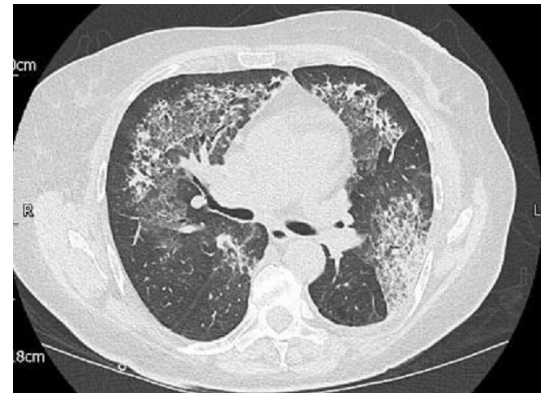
High-resolution CT (GE Healthcare Discovery CT 750 HD) showing a combination of bilateral peribronchovascular dense consolidative foci with reticulation and surrounding ground-glass shadowing, resulting in a crazy paving-type appearance.
